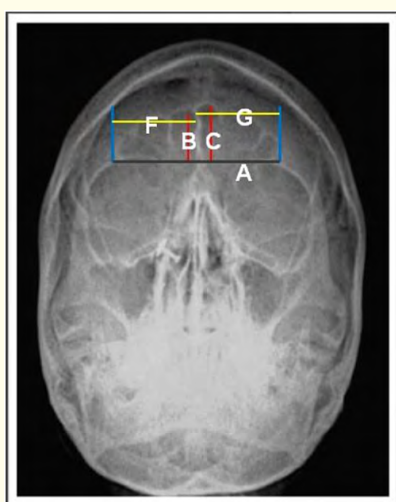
Digital PNS radiograph showing borders of the frontal sinus and identification of the measurements. A (baseline): The lower border of the frontal sinus. B, C: The greatest height of each side. F, G: The largest width of the frontal sinus.
